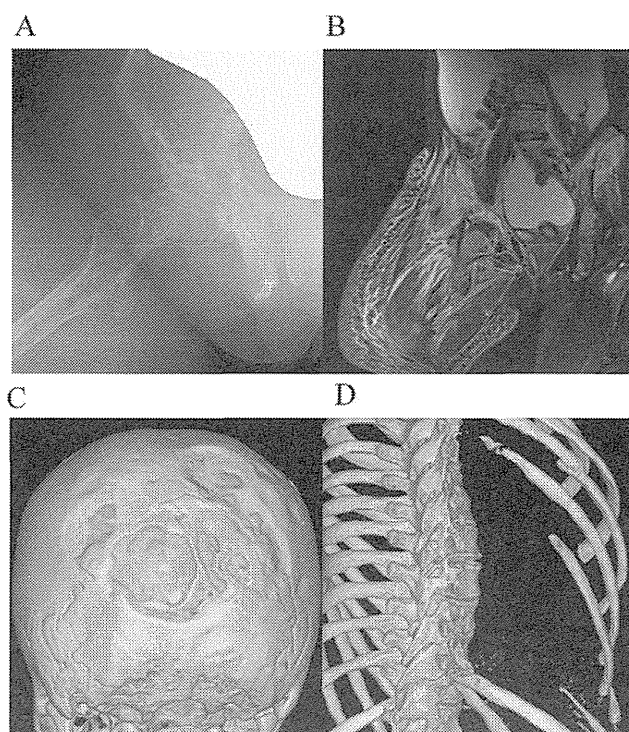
Radiological findings of patients with GSD. (A and B) Thirteen-year-old female with GSD involving right lower extremity, right pelvis, spine, abdomen, and right thorax. (A) Plain radiograph of the right pelvis shows osteolysis at the proximal femoral shaft as well as the pelvic bone. (B) Coronal fat suppressed in T2-weighted image of the pelvis demonstrates extensive high signal intensity in the soft tissue surrounding the femur as well as subcutaneous fat tissue. Involved right pelvis shows high signal intensity secondary to osteolysis. Also visible is a large amount of ascites. (C) Nine-year-old male with GSD involving the occipital and temporal bones. Posterior view of 3D CT imaging shows almost complete resorption of the occipital bone. (D) Thirteen-year-old female with GSD involving the ribs. Right oblique posterior view of 3D CT shows multiple osteolysis and fracture of the posterior portion of the right 5–10 ribs. CT, computed tomography; GSD, Gorham–Stout disease (GSD).
